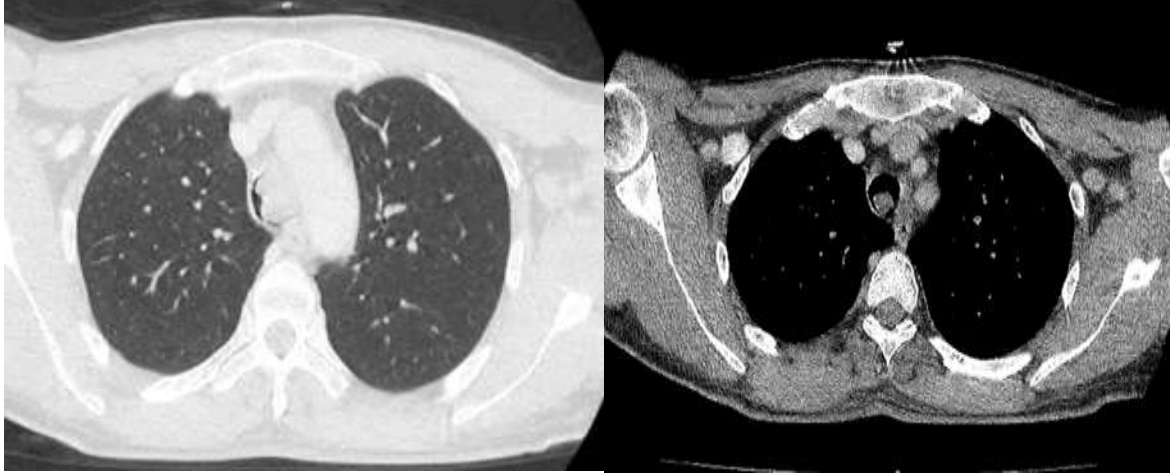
(A, B):- Thoracic CT scan in parenchymal window A and mediastinal window B showing an intratracheal, quasi-stenosing, budding tissue lesion process.
